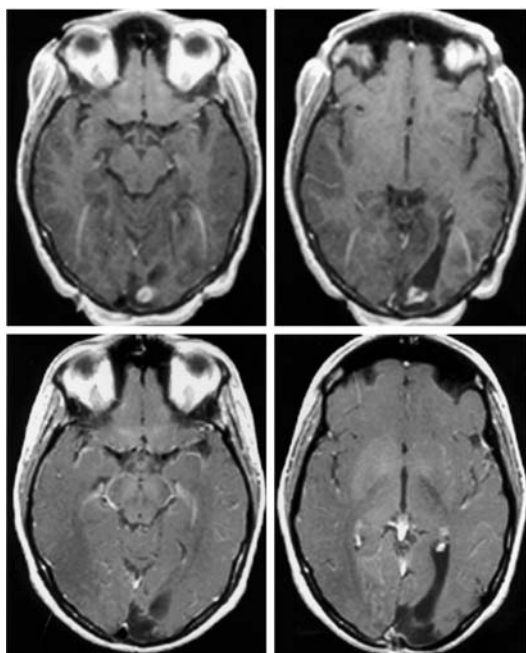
Axial T₁-weighted postgadolinium MR images obtained in a 23-year-old woman with a recurrent left occipital ODG. The tumor was Grade 1 6 years earlier, but another biopsy was not obtained prior to radiosurgery. *Upper*: Images acquired at the time of radiosurgery. *Lower*: Images obtained 24 months after radiosurgery demonstrating no visible tumor.
